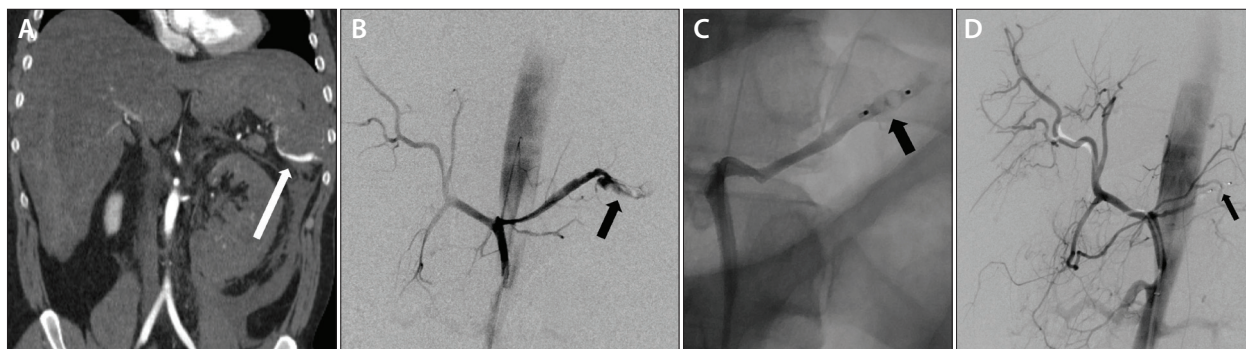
A 47-year-old patient presented to the emergency department after a motor vehicle accident. His vital signs were fairly stable. Contrast-enhanced CT (coronal reformat) demonstrated active contrast extravasation (arrow) below the lower pole of the spleen, indicative of splenic rupture (A). In addition, perisplenic, perihepatic, and retroperitoneal hematomas were present. Intervention was performed under conscious sedation. Access was obtained via the right femoral artery, and a long 4-F introducer sheath was inserted. A 4-F Cobra catheter was used to select the patient's celiac artery, and selective angiography was performed, which demonstrated complete splenic artery rupture (arrow) (B). The diagnostic 4-F catheter was advanced to the bleeding site, and a vascular plug (AVP 4) was deployed proximally in the mid splenic artery (arrow) (C). A final arteriogram showing the vascular plug (arrow) in the mid splenic artery demonstrated no contrast extravasation (D).
